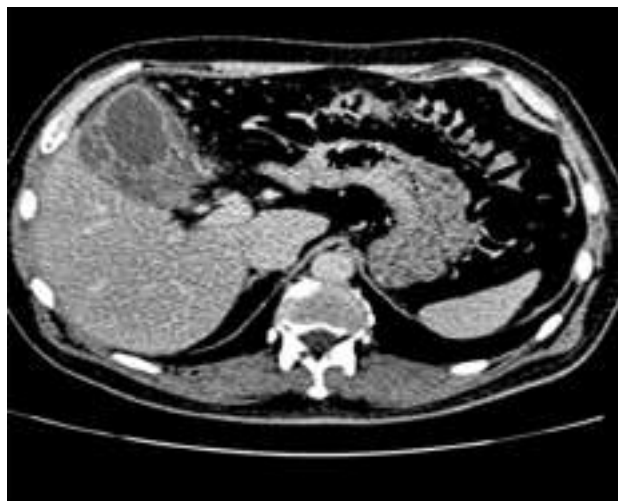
Contrast-enhanced abdominal CT scan showing a localized pericholecystic abscess
